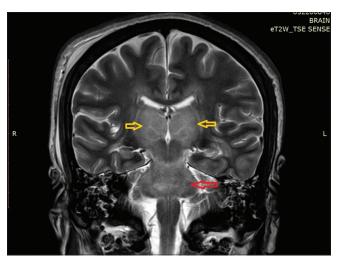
Magnetic resonance imaging coronal image shows hyperintense signal in bilateral thalami (yellow arrow) and midbrain (red arrow)
